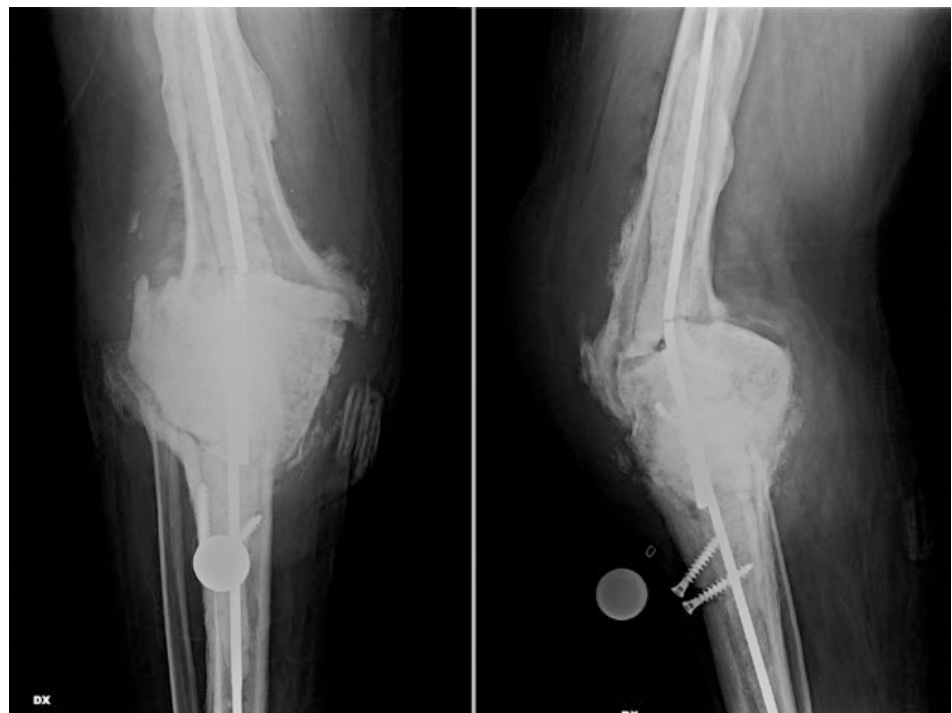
Preoperative x-rays of the patient showing the rupture of the cemented static spacer and the two screws that were used to fix the hernia mesh
